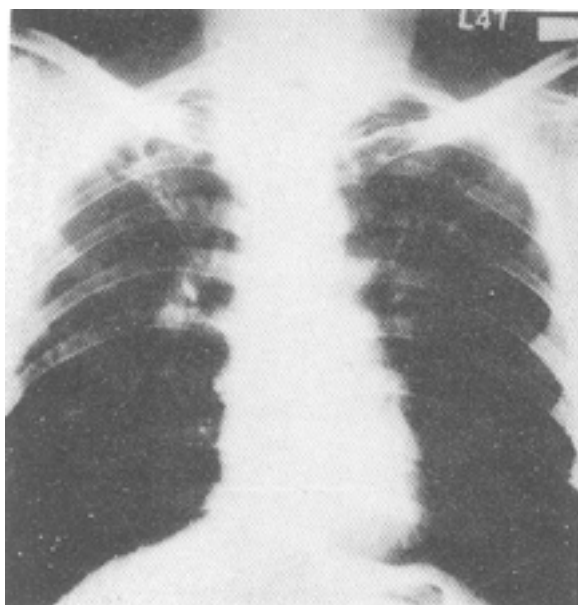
Post therapy chest radiograph showing marked resolution of the lesions
